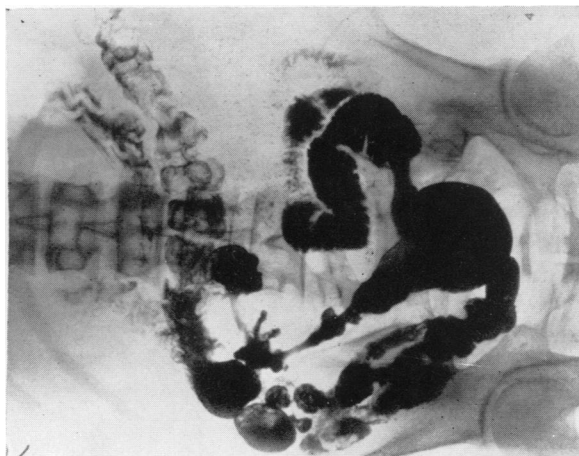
X-ray showing extent of the involvement of the ileum; relatively unchanged after 12 years (c.f. Cooke, 1951, Fig. 194).
